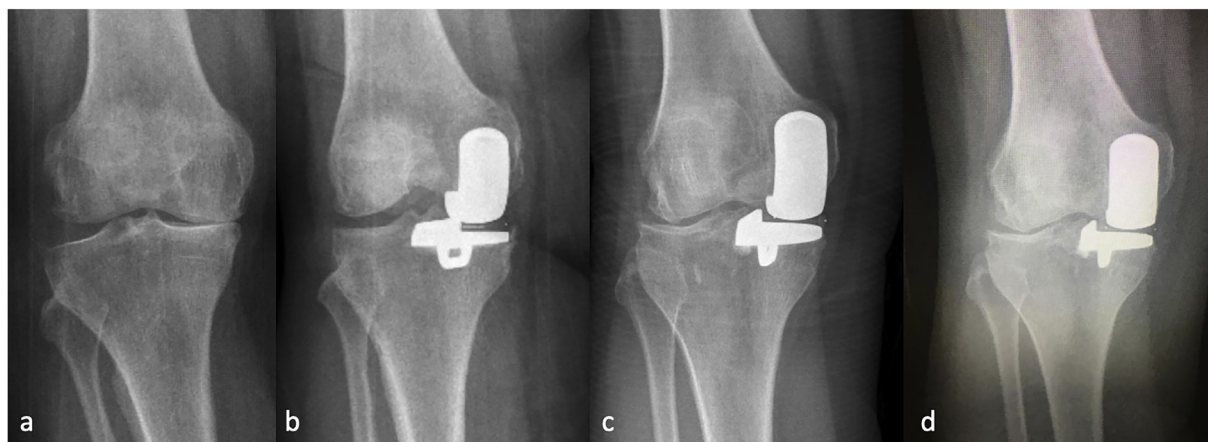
Lateral compartment osteoarthritis progression in a 64-year-old patient. (a) Preoperative, (b) postoperative one-year, (c) postoperative four-year, and (d) postoperative six-year follow-up radiographs.
